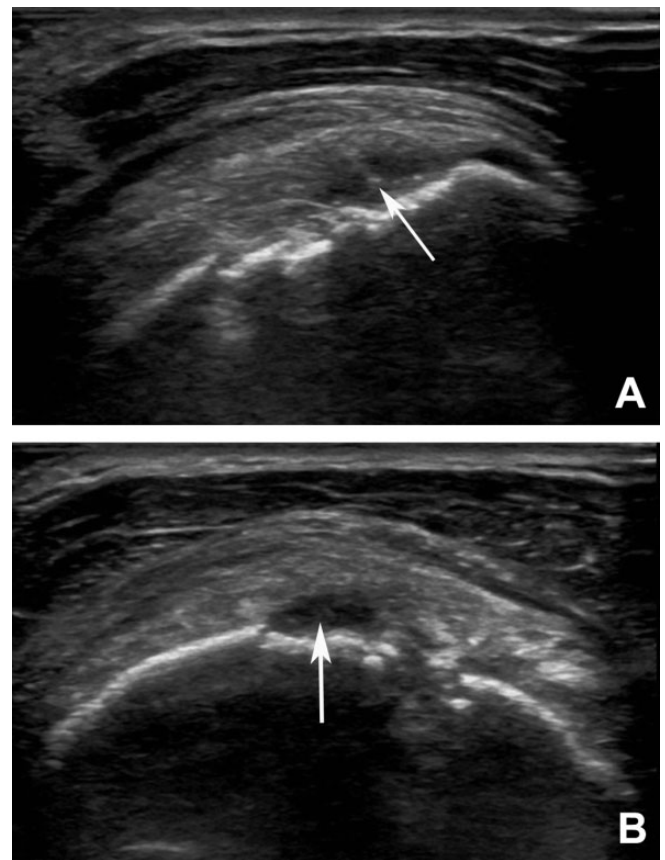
Ultrasound (A) long-axis and (B) short-axis views of an intact supraspinatus tendon with minor residual partial tear. Arrows indicate location of repair with minor residual partial tear.
